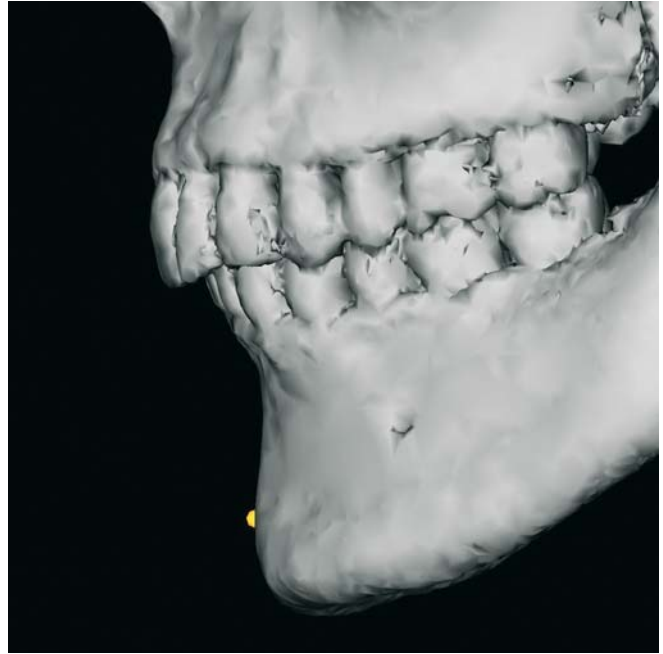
Pogonion. Profile view left (3-D CT, patient K.C.)
